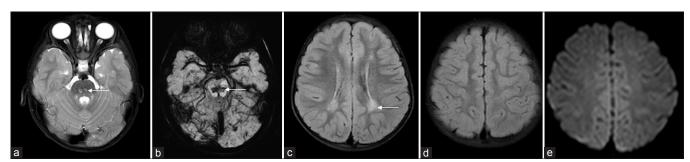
Follow-up magnetic resonance imaging T2 axial image (a) small persistent hyperintense foci in the pons. Susceptibility-weighted image (b) persisting hypointensity suggestive of hemosiderin deposits. Minimal persistent posterior periventricular hyperintensity is seen on fluid-attenuated inversion recovery axial image (c). Fluid-attenuated inversion recovery axial image and diffusion-weighted image at a higher level (d and e) complete resolution of findings
